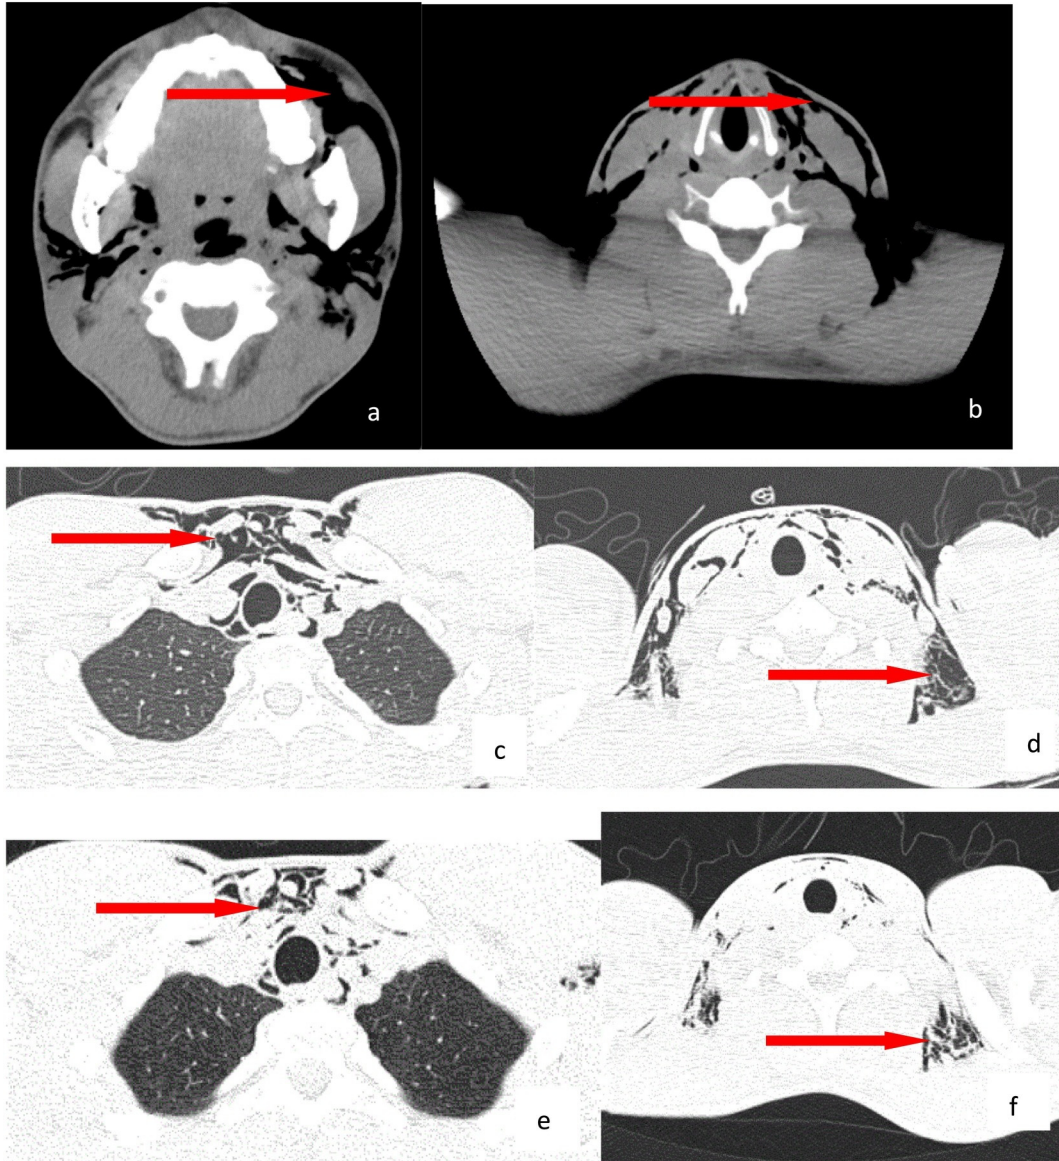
a CT demonstrated subcutaneous emphysema in maxillofacial region (arrow). b CT demonstrated subcutaneous emphysema in neck (arrow). c CT demonstrated emphysema in mediastinum (arrow). d CT demonstrated subcutaneous emphysema in left chest and left back (arrow). e CT rechecked two days later demonstrated less emphysema in mediastinum (arrow). f CT rechecked two days later demonstrated less subcutaneous emphysema in left chest and left back (arrow).
